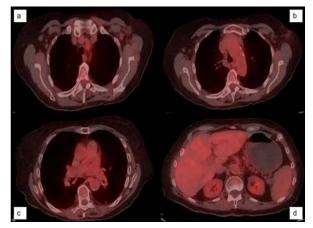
Corresponding axial positron-emission tomography/ computed tomography images demonstrating interval resolution of (a) axillary, (b) mediastinal, and (c) hilar lymphadenopathy, as well as resolution of (d) splenomegaly, with no areas of increased hypermetabolism.
